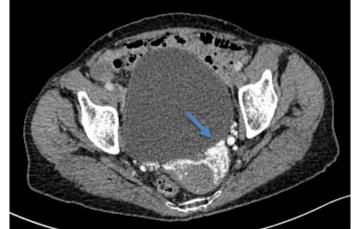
Axial contrast-enhanced CT scan showing pelvic varices on the left side, including uterine-ovarian and para-uterine varices
